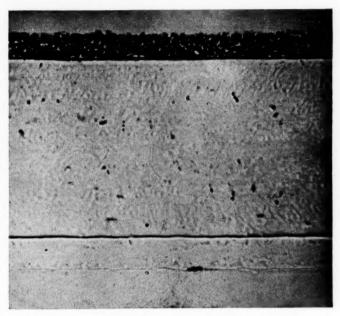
Cross-section of film exposed directly to X-ray beam.
